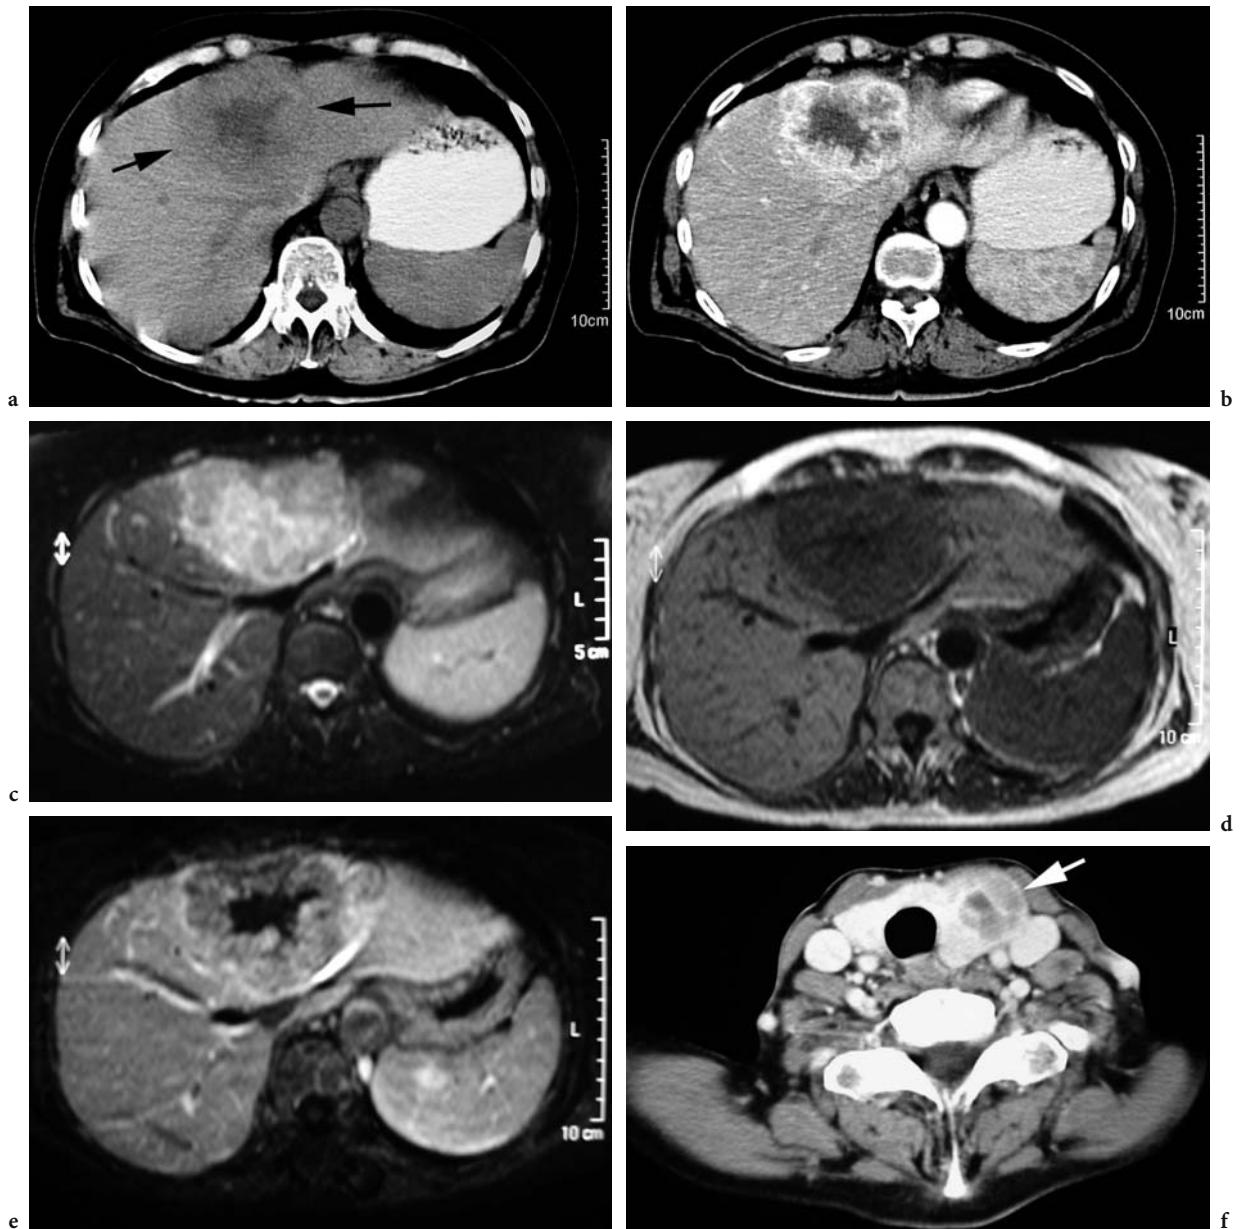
Liver and thyroid metastases in a 69-year-old woman who underwent left nephrectomy for renal cell carcinoma. a Axial unenhanced CT scan shows an ill-defined large hypodense hepatic lesion with central necrosis (*arrows*). b This lesion strongly heterogeneously enhances after contrast injection and its contours are more conspicuous and its central necrosis is more obvious. This lesion is hyperintense on c axial turbo spin T2-weighted MR image and hypointense on d fast-field-echo T1-weighted MR image. The tumoral enhancement is less obvious on e contrast-enhanced fast-field-echo T1-weighted MR image than on CT. f Axial contrast-enhanced CT of the neck shows large heterogeneous nodule of the left thyroid lobe (*arrow*).
